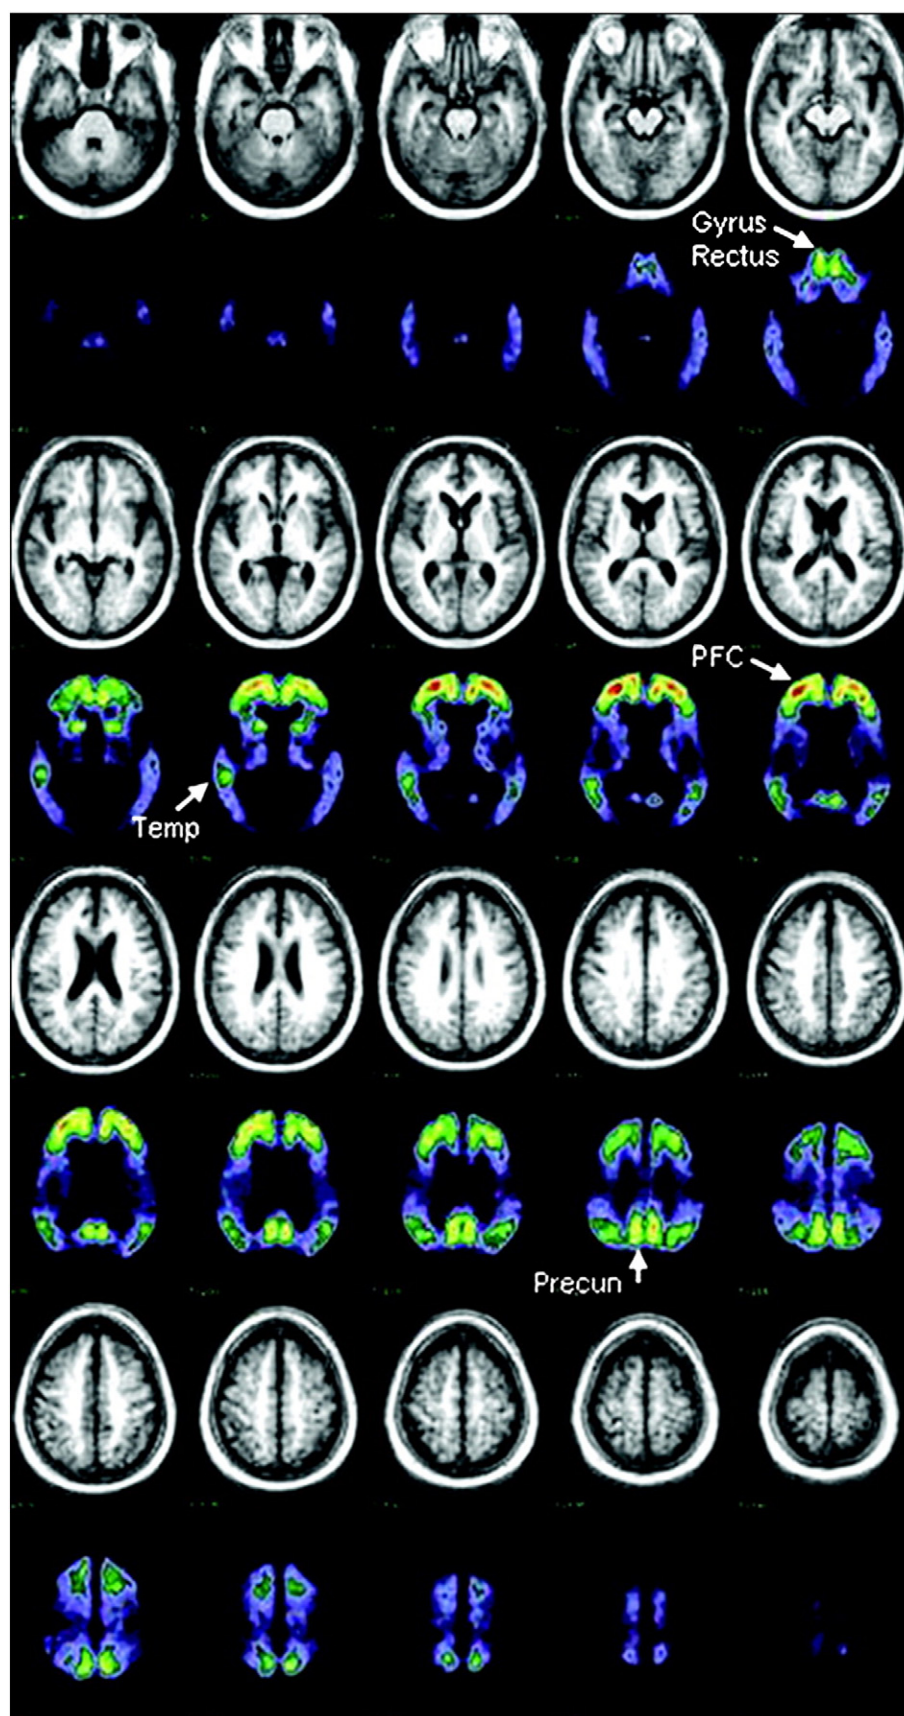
Mean MRI and PET [^{11}C]PIB distribution in a standard atlas coordinate system from 10 subjects with dementia of the Alzheimer type. PET data represent [^{11}C]PIB activity in the late (30 to 60 min after injection) distribution and has been normalized to standardize display and increase contrast. Brain areas used to detect raised [^{11}C] PIB uptake in non-demented subjects are indicated with arrows. PFC = prefrontal cortex; Temp = temporal cortex; Precun = precuneus region. Reproduced with permission from Ref. [84].
